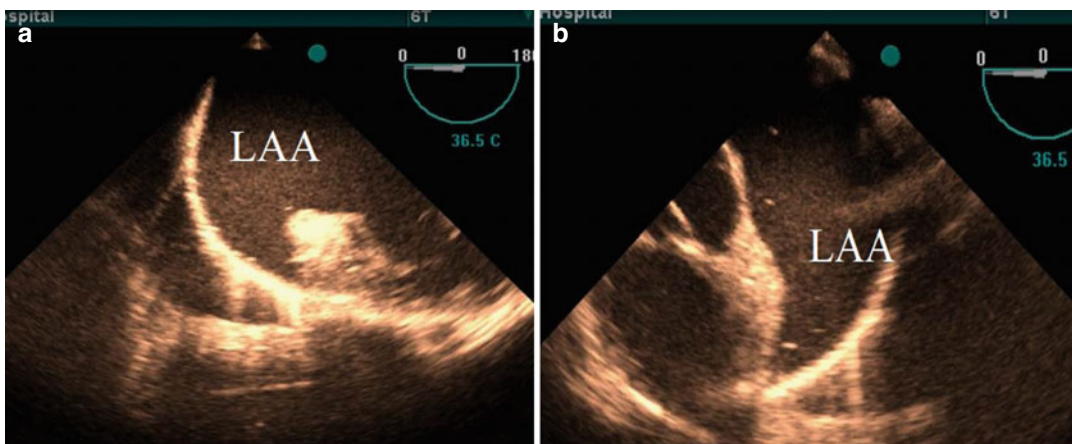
(a, b) Transesophageal echocardiography, showing left isomerism with bilateral left atria. LAA left atrium appendage
